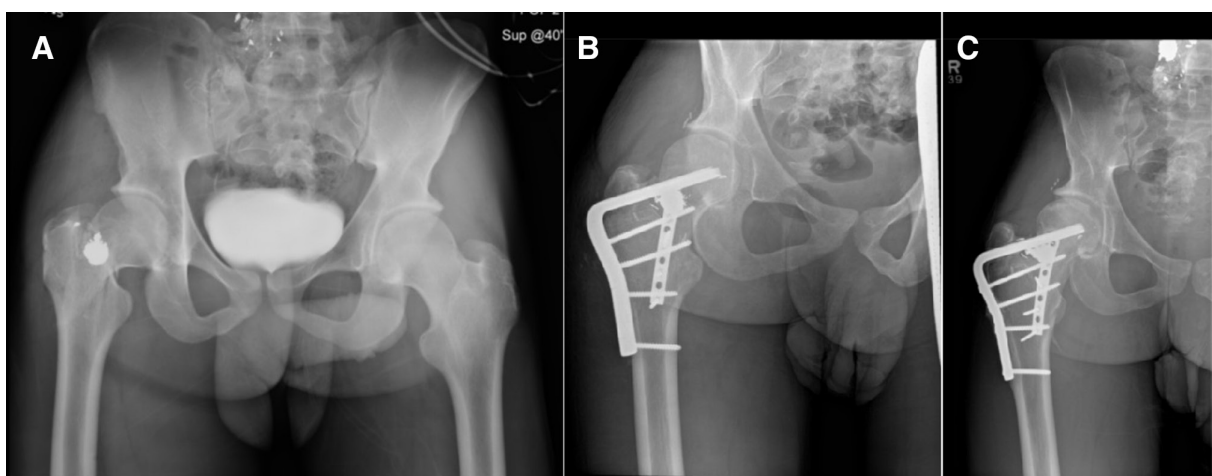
(A) Preoperative anterior-posterior (AP) pelvic radiographs demonstrating a displaced right ballistic femoral neck fracture. (B) One-month postoperative AP hip radiograph demonstrating fixation with a blade plate. Additionally, a 2.7 mm buttress plate was applied anterior-inferiorly on the femoral neck to aid in achieving reduction of the femoral neck. (C) One-year follow-up AP hip radiograph demonstrating healing of the femoral neck with no breakage of implants.
